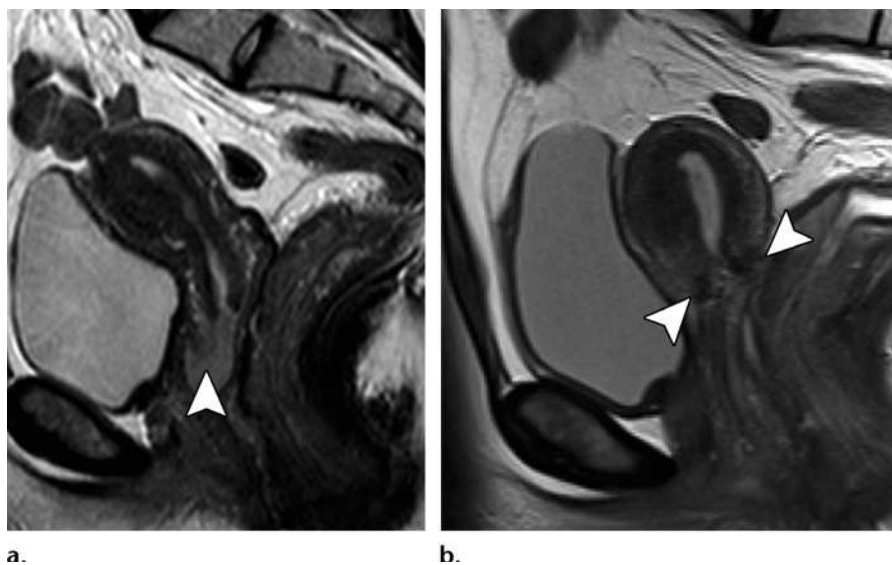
Squamous cell carcinoma in a 29-year-old woman with intermenstrual bleeding and a positive result at cervical cone biopsy. The patient had no children and therefore wished to preserve her fertility. (a) Sagittal T2-weighted image shows an exophytic, 2-cm, intermediate-signal-intensity tumor arising from the anterior cervical lip (arrowhead). (b) Sagittal T2-weighted image after trachelectomy shows the typical appearance of an end-to-end uterovaginal anastomosis (arrowheads).
